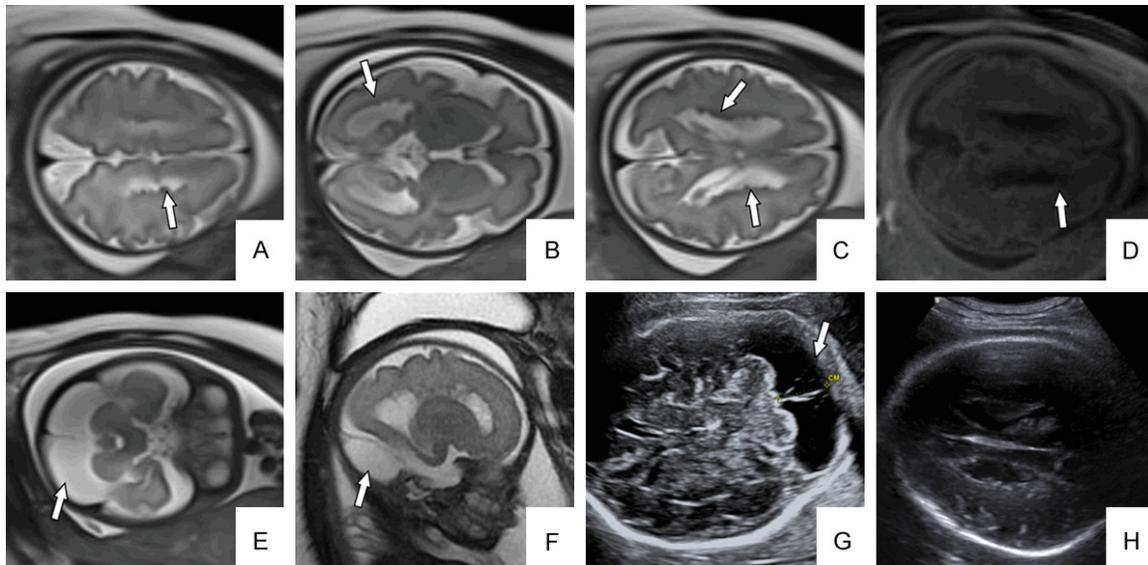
A fetus diagnosed with arachnoid cyst and tuberous sclerosis at 26 gestational weeks. Prenatal MRI demonstrated multiple small nodules at bilateral subventricular zones (A-D, arrows) and a large arachnoid cyst at posterior cranial fossa (E and F, arrows). However, only a large arachnoid cyst could be found on ultrasound image (G). The nodules were difficult to identify and were easily missed on the ultrasound image (H).
